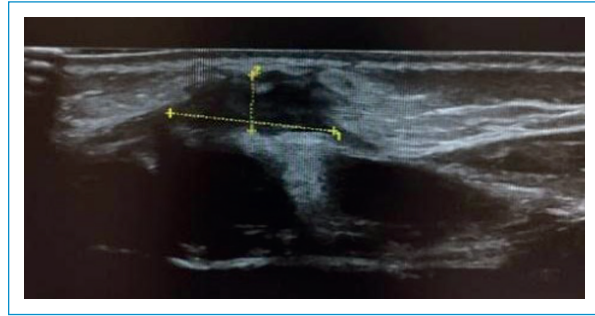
Case 2: ultrasound of sternal lesion with dumbbell-shaped subcutaneous lesion.
